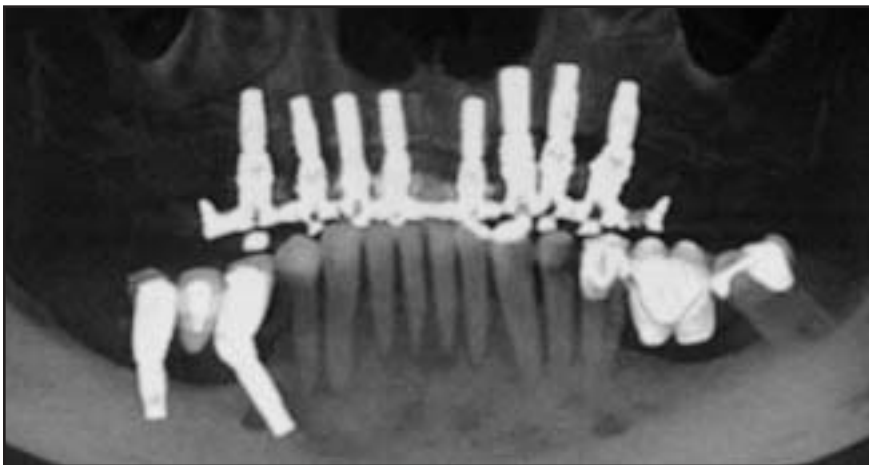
Three-year follow-up panoramic radiograph. Note the presence of adequate bone surrounding the dental implants.
